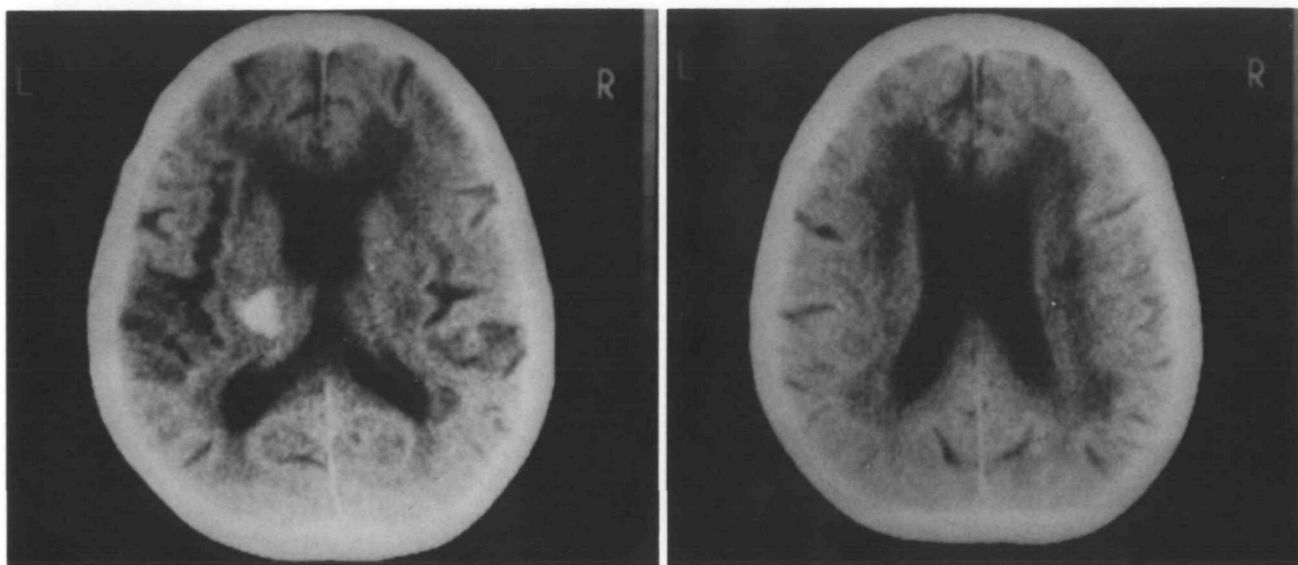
Case 4. Computed tomographs of another patient with leukoaraiosis and intracerebral hematoma. Hemorrhage is located in posterior part of internal capsule and thalamus.
